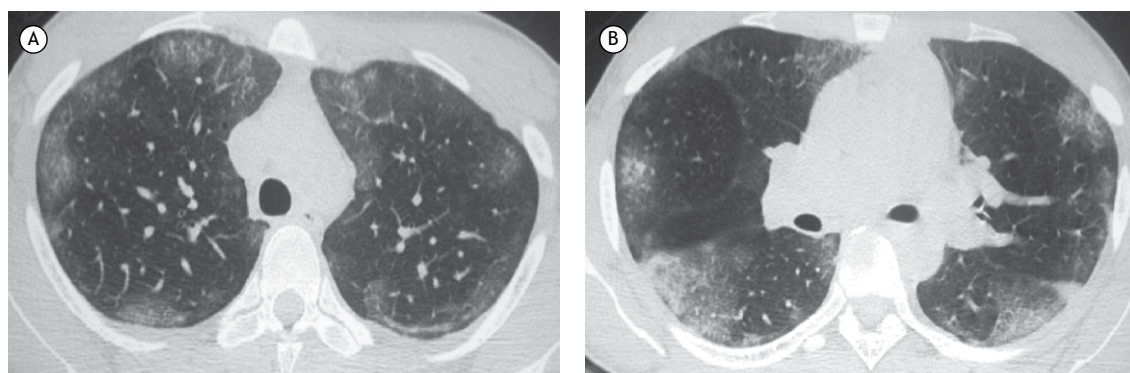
Axial CT scans of the chest (upper and middle lung fields, in A and B, respectively) showing ground-glass opacities and patchy areas of consolidation in the lung periphery.
